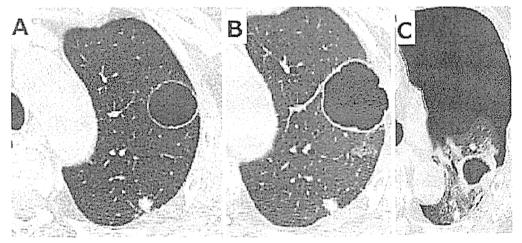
A chest CT scan shows a subpleural thin-walled cyst at the left upper lobe (A). There was a gound glass appearance around the cyst revealing the hemorrhage of tumor vessels. The cyst had grown significantly larger 2 months later (B). A CT scan shows left pneumothorax (C).
